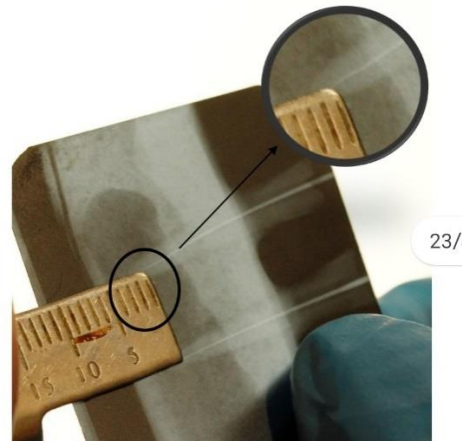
Determination of tooth length by conventional radiography
